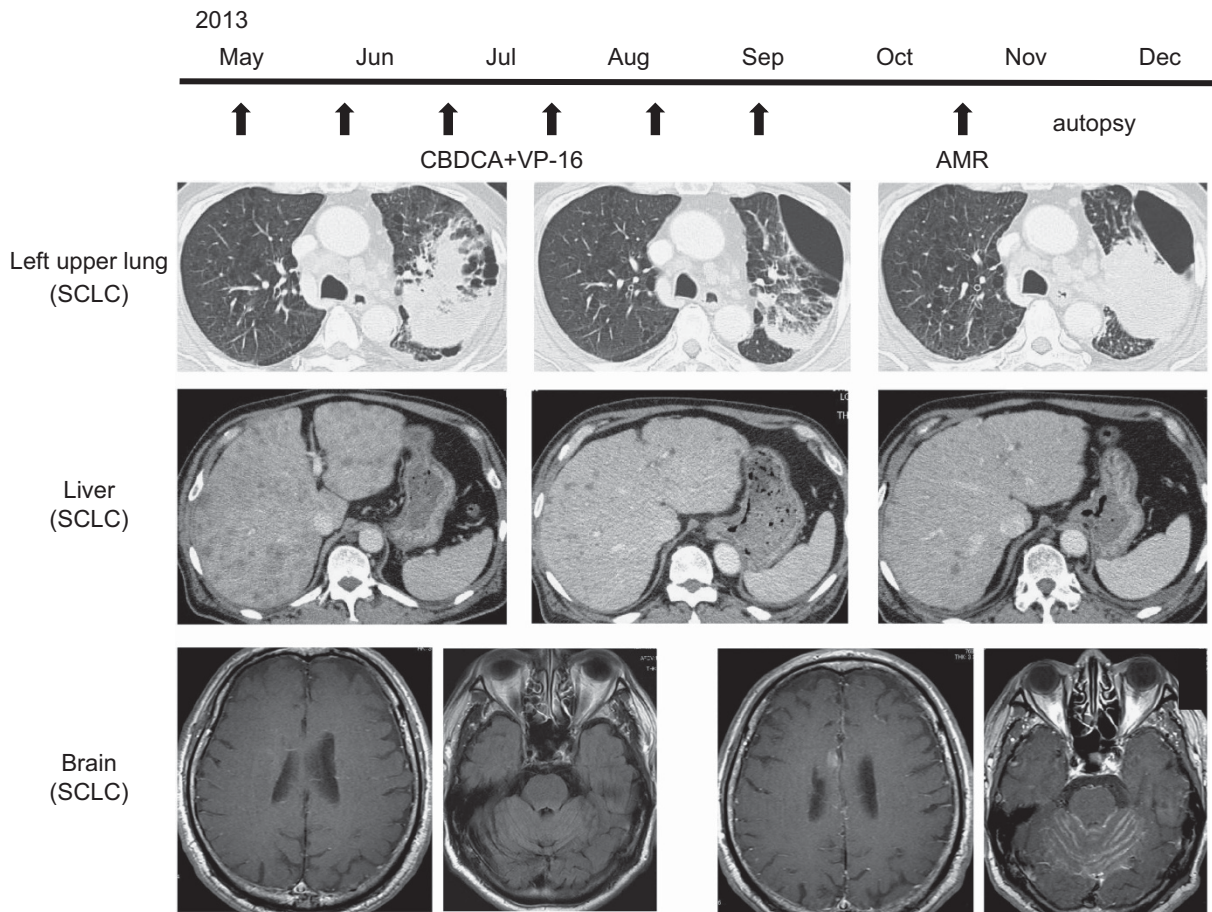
Clinical course of the SCLC patient who provided autopsy tissues. In May 2013, a 64-year-old Japanese man was admitted with increased shortness of breath. Consolidation was found in the left upper lung, and wall thickness of the pulmonary bulla was found in the right lower field in chest radiographs. He was diagnosed with lung synchronous carcinoma with multiple liver metastases. Bronchoscopic biopsy revealed small lung cell cancer (SCLC) from left B¹⁺² and squamous cell carcinoma from right B⁶. These synchronous carcinomas responded to first-line chemotherapy CBDCA+VP-16 (a total of six courses). But consolidation of the left upper lung (SCLC) worsened only 3 weeks after the last course of chemotherapy. Chemotherapy was changed to amrubicin, but disturbance of consciousness gradually appeared and worsened. Magnetic resonance imaging (MRI) findings and cytology of the cerebrospinal fluid (SCLC) were consistent with brain metastasis and meningeal carcinomatosis. In November 2013, he died, and the patient underwent autopsy. We obtained SCLC tissues of the left upper lung, liver metastasis and brain metastasis.
